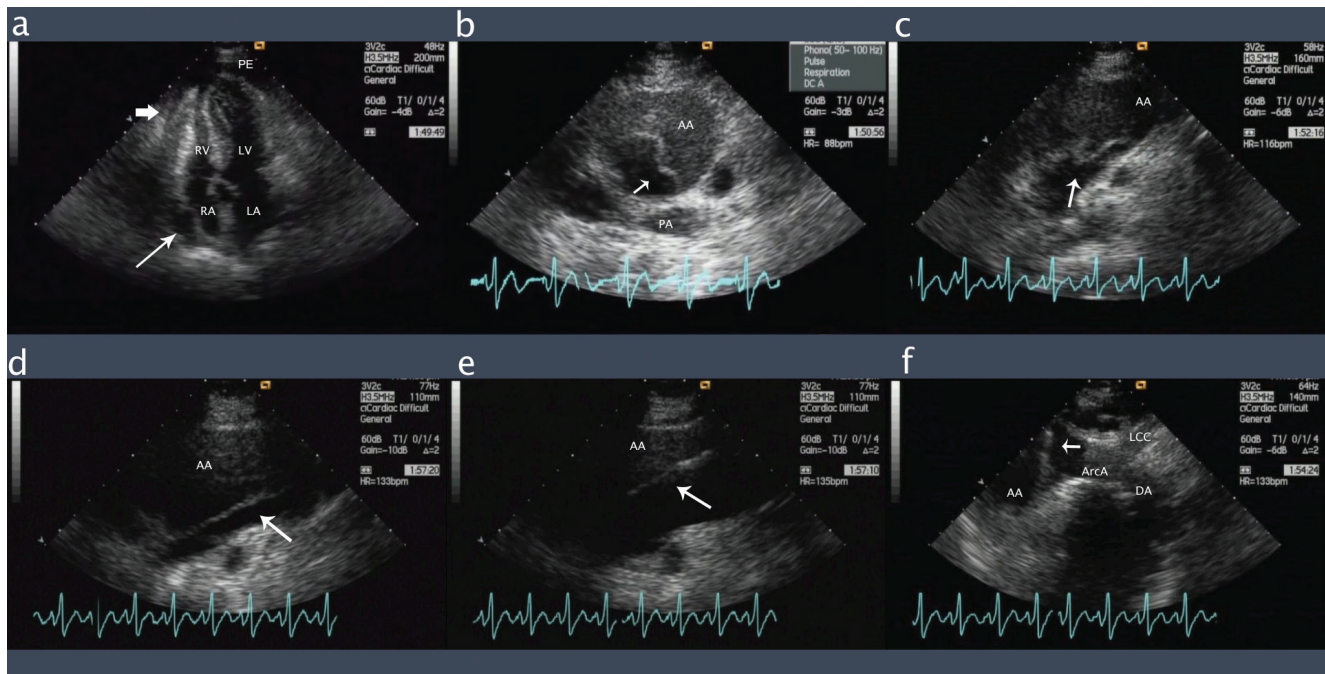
Right parasternal echocardiographic view of the patient.
